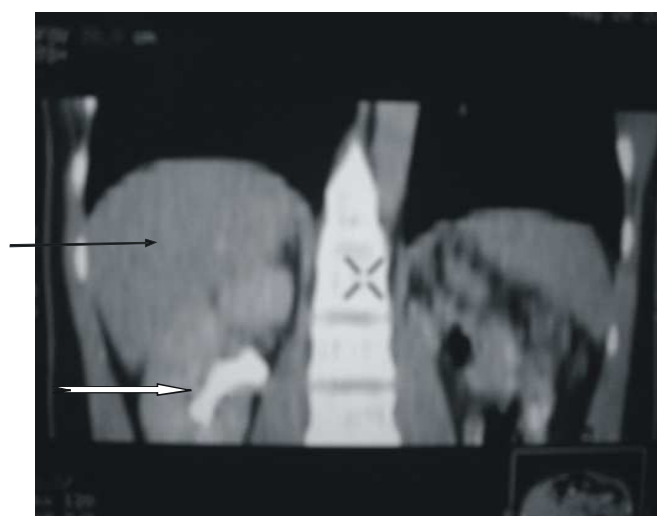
Coronal reconstructed CT image showing the right kidney (white arrow) below the liver (black arrow).
